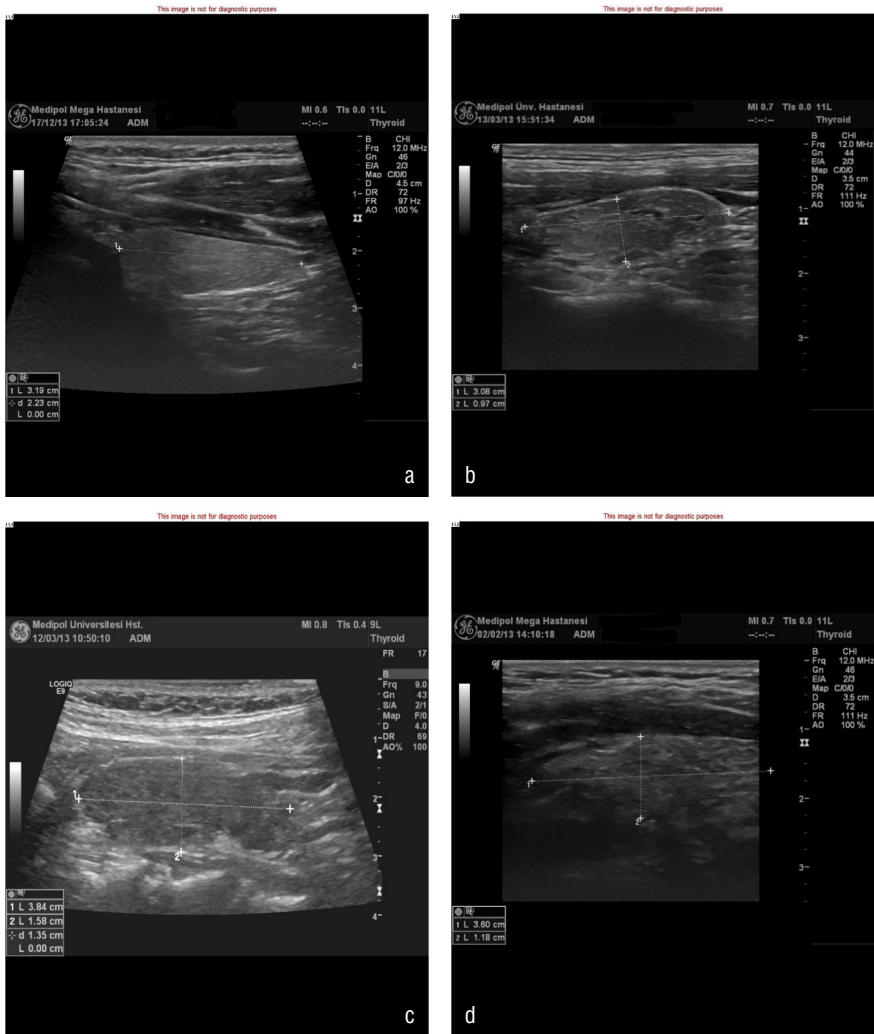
(a) Group 1 (control cases) normal thyroid gland ultrasonography, (b) Group 2 (intermediate/early-stage cases); minimal parenchymal hypoechoogenicity and suspected heterogeneity, (c) Group 3 (active and advanced-late stage) parenchyma was heterogeneous/hypoechoogenic, (d) Group 3 (chronic stage) with parenchyma was heterogeneous/hypoechoogenic.
